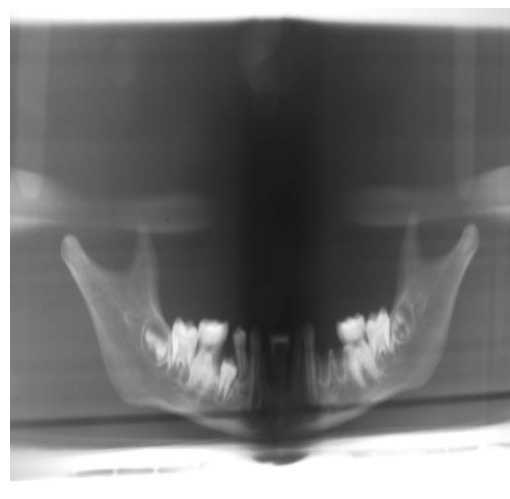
Image represents the panoramic radiograph of mandible Evaluation of image
